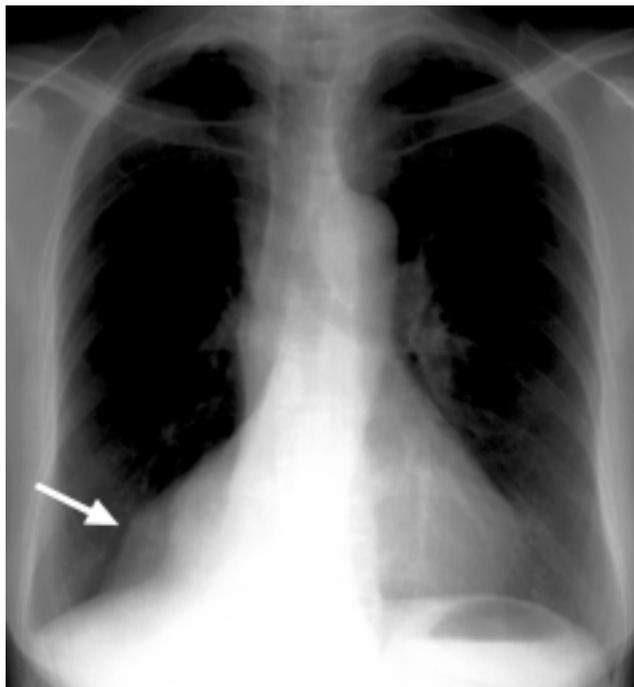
Chest roentgenogram. Chest roentgenogram on May 2, 2000, showed an abnormal shadow in the right lower lung field (arrow).
